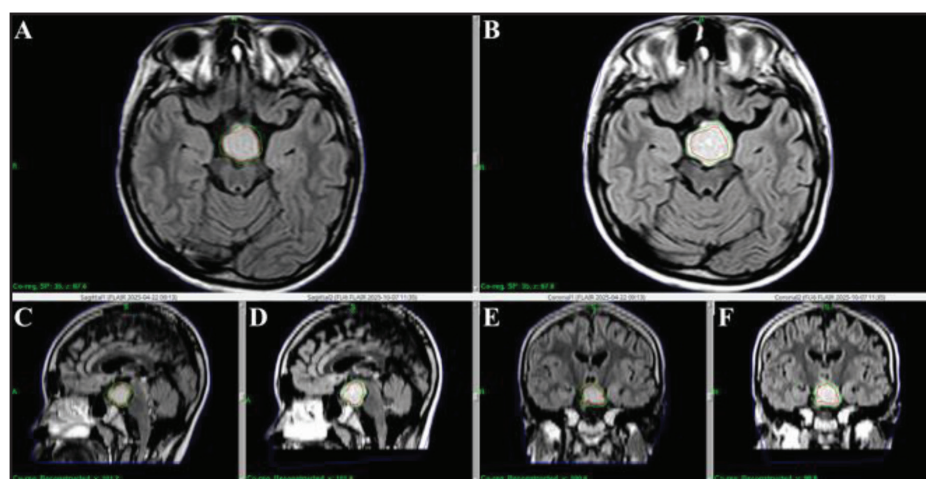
Comparison of pre-treatment and 6-month follow-up MRI in Case 3. Axial, sagittal, and coronal T2-weighted FLAIR images obtained before GKRS (A, C, and E) and at 6 months after GKRS (B, D, and F). Images demonstrate an interval increase in lesion size and signal abnormality following radiosurgery, consistent with treatment-related radiological change.
